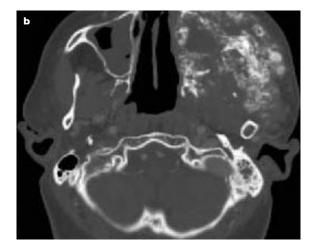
Axial (a) soft tissue and (b) bone window, and (c) coronal bone window CT images show a large bony mass in the left maxilla that completely destroys the left antrum. The bony mass extends into the left orbit, left temporal bone, as well as the nasal cavity.
